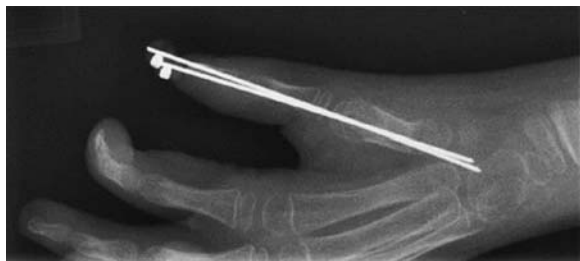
Six-week postoperative radiograph demonstrating a healed osteotomy site. Courtesy of the Shriners Hospital for Children, Philadelphia.
